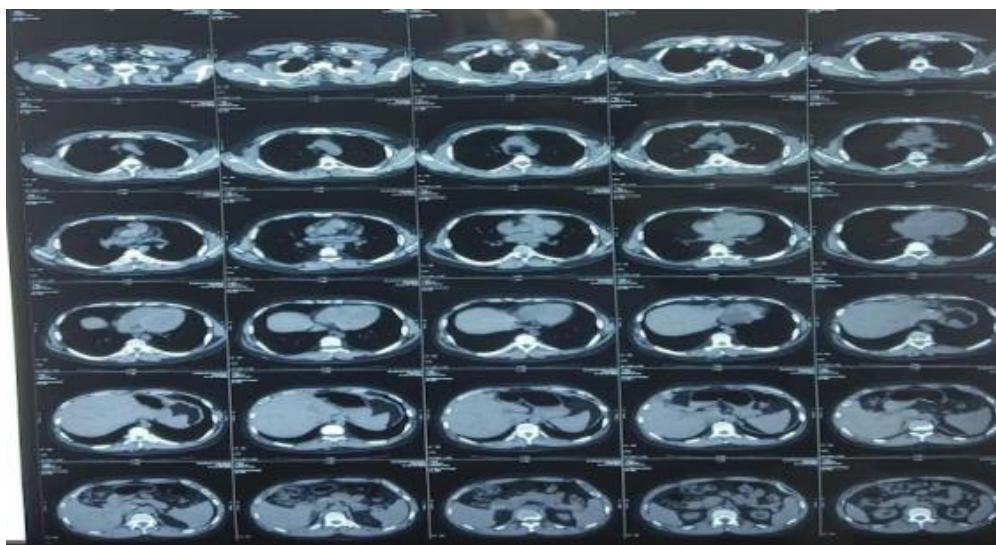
HRCT chest (soft-tissue window) – inhomogeneous appearance with areas of ground-glass opacities, interlobular interstitial thickening, mosaic attenuation, and right hilar node
